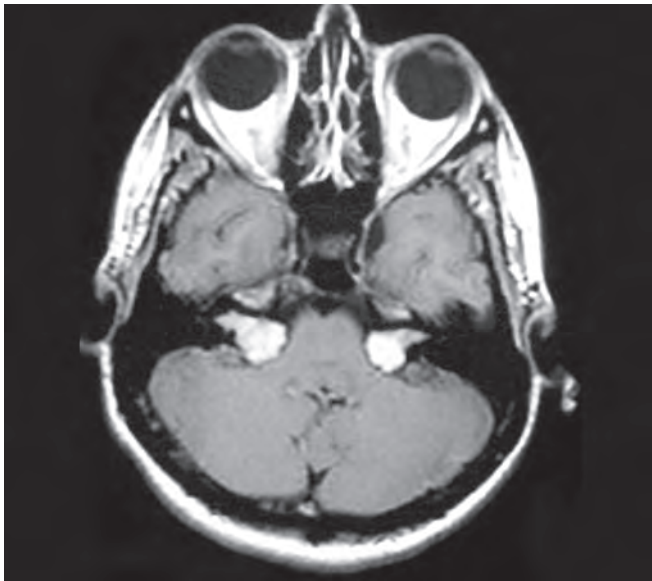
Contrast magnetic resonance imaging of the brain T1W axial view showing bilateral small vestibular schwannomas enhancing with contrast
